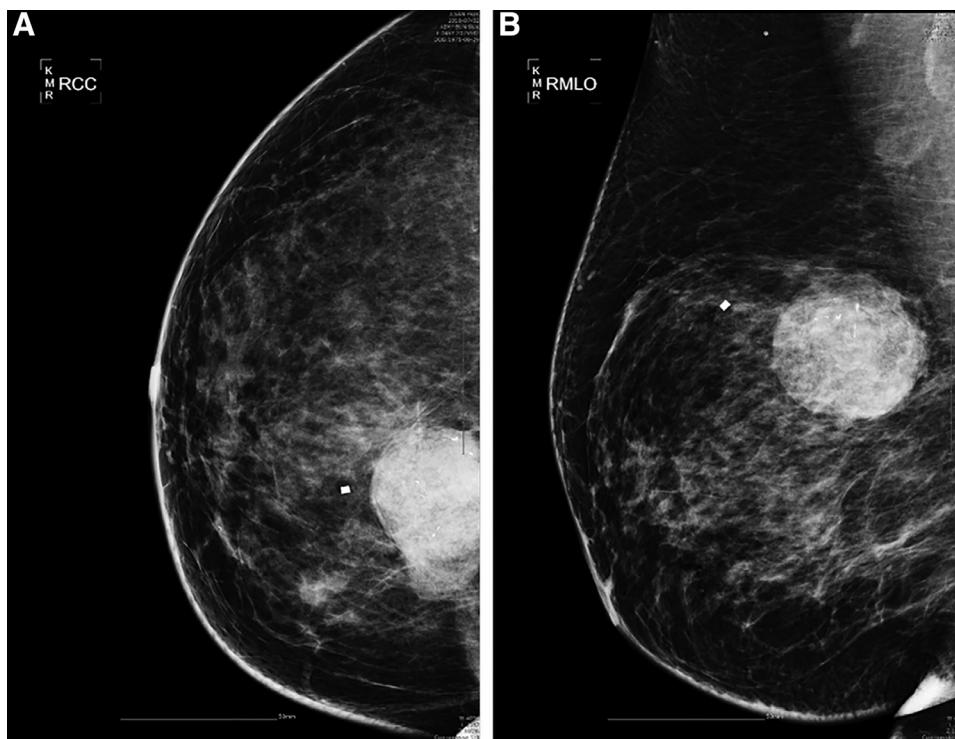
Standard mammographic view. (A) Right craniocaudal and (B) mediolateral oblique projections reveal a high-density mass with a partially indistinct margin in the upper medial portion. Asymmetry visible in the medial portion of the craniocaudal projection had no correlated lesion on ultrasound imaging.
